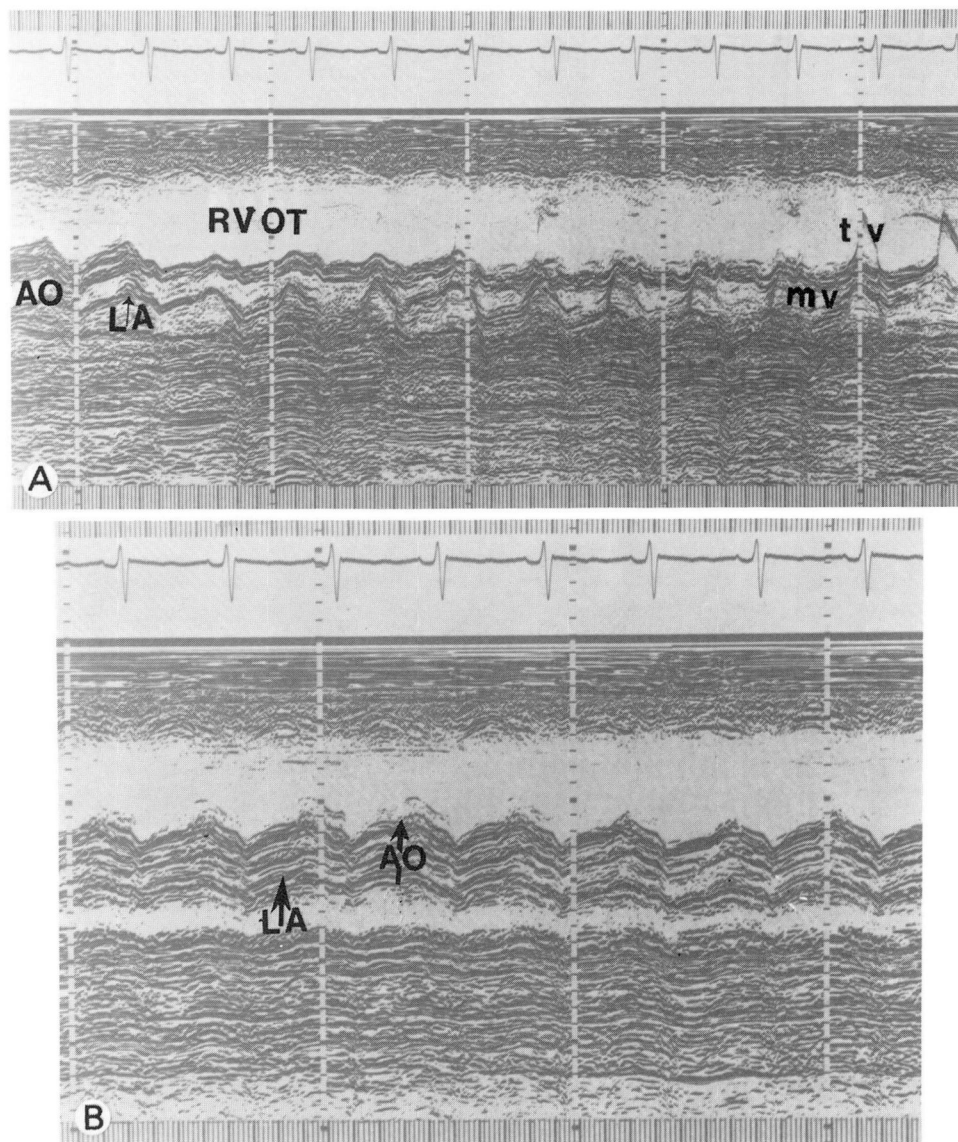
M-mode echocardiogram in patient 8 demonstrating the markedly dilated right-sided heart chambers with compression of the mitral valve, the left ventricle, and left atrium. RVOT = right ventricular outflow tract, and other abbreviations as in above *Figures*. B. Left atrial aortic root dimensions demonstrating a small atrium.
